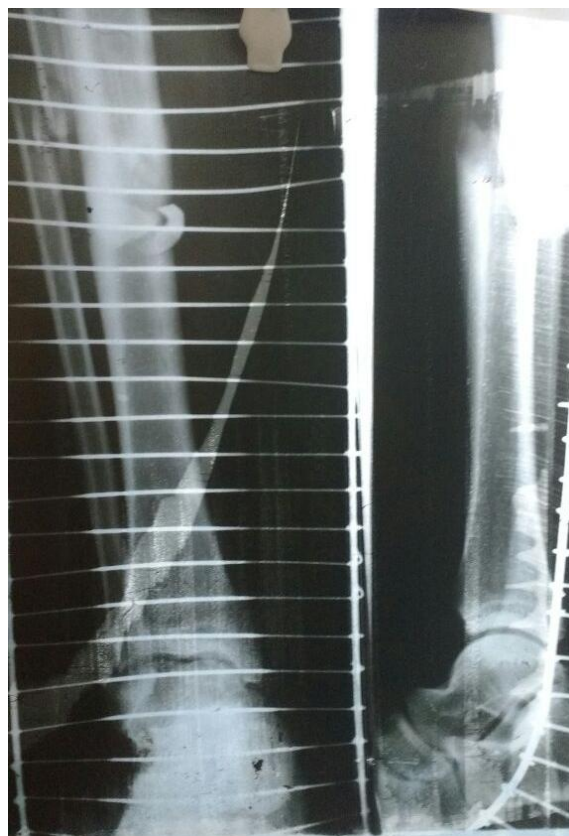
Preoperative X-ray of fracture shaft of tibia
